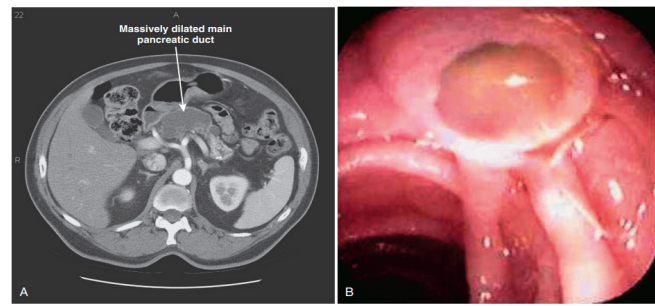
If an intraductal papillary mucinous neoplasm (IPMN) is found in the main duct gland, the patient will be diagnosed with recurrent acute pancreatitis (RAP). A CT scan reveals that the pancreatic duct has been significantly enlarged. The side-viewing endoscopy allows for the discovery of a gaping papilla that is accompanied by mucus extrusion. (2)
